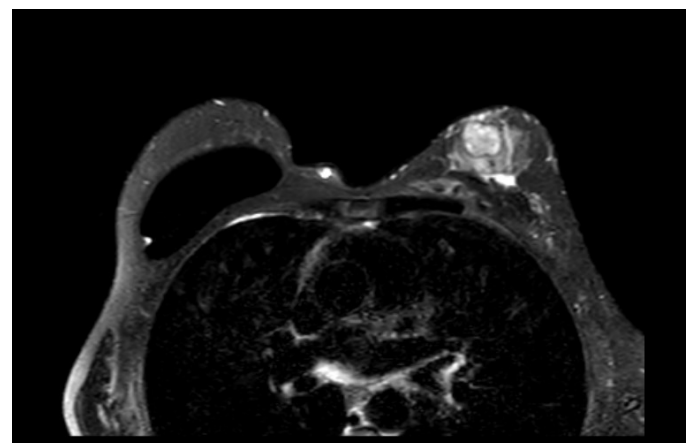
Breast MRI shows a well-circumscribed heterogeneous contrast-enhancing lesion in the upper inner quadrant of the left breast and prosthesis in right breast
